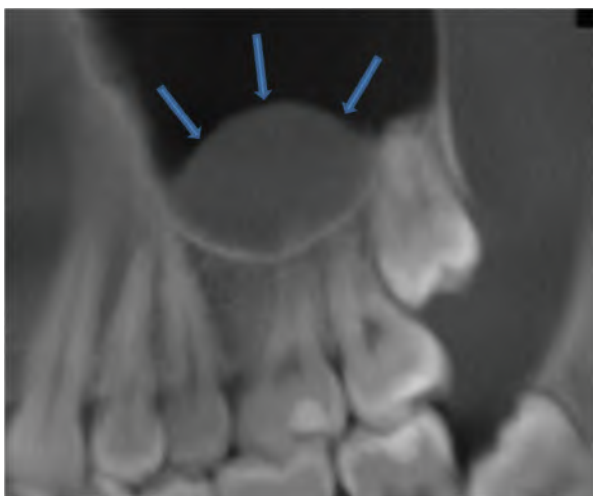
A section of a panoramic reconstruction from a CBCT scan showing a well-defined, dome-shaped, homogenous and faint radiopacity consistent with an *antral pseudocyst* (aka: sinus mucocele). This is a common radiographic finding in the sinus and is usually clinically inconsequential. Also, in this case, there were no signs or symptoms associated with this lesion and the teeth and pulps were normal. Lack of a corticated rim of bone (arrows) is highly suggestive that this does not represent a periapical cyst. Compare this image to the case of periapical cyst shown in Figure 10-26C & D where a thin rim of corticated bone can be seen at the periphery of the cyst lifting up from the floor of the sinus. Because antral pseudocysts arise from the lining of the sinus they do not alter or lift the antral bone as seen here. (Courtesy of Dr. Parish P. Sedghizadeh, Los Angeles, CA.)
